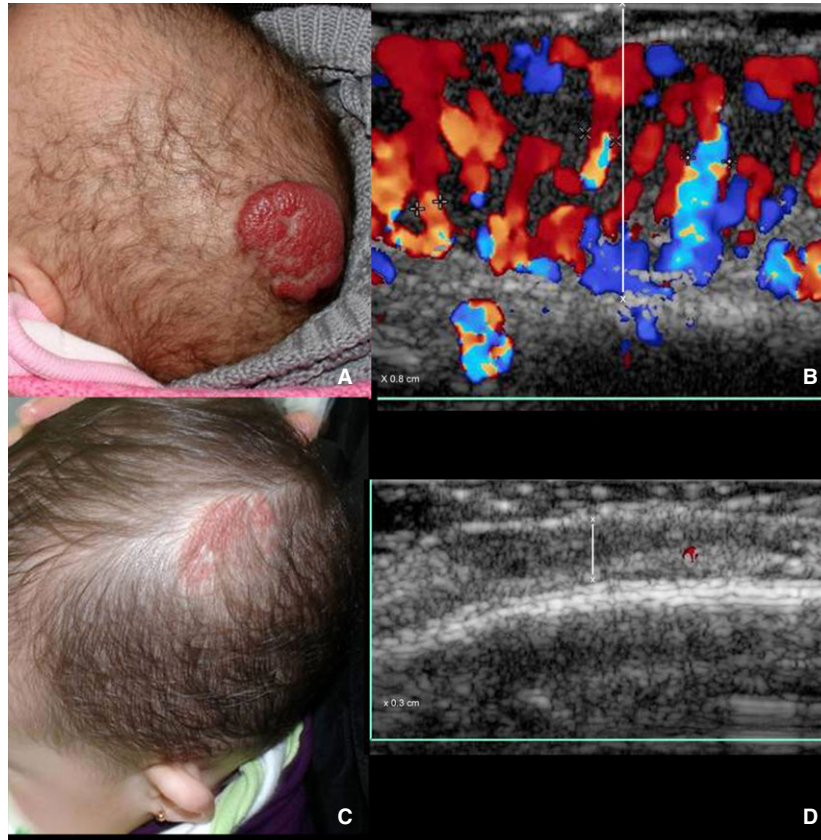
Hemangioma on the scalp. (A) Clinical evaluation before treatment. (B) Color Doppler ultrasound (CDU) evaluation before treatment shows hypervascularity within the lesion that involves the dermis and hypodermis. (C) Clinical follow-up at 3 months. (D) CDU follow-up at 3 months shows flattening and hypovascularity of the same lesion. Thickness (x) measurements are described in B and D (CDU longitudinal axes).
